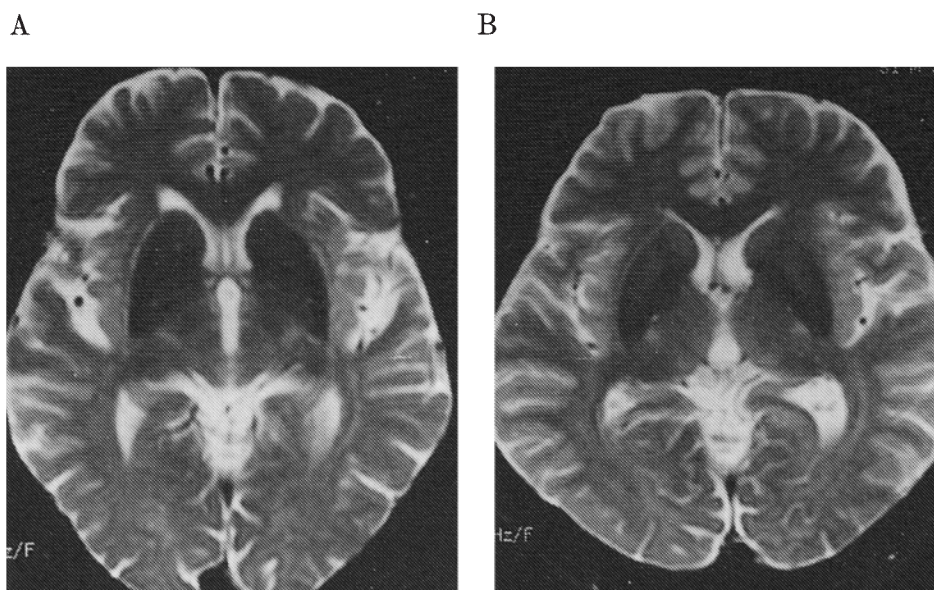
MRI of the brain of the patient with HypoCPGM (A) and her son (B). T2-weighted echo-planar image shows reduced signal from the putamina.
